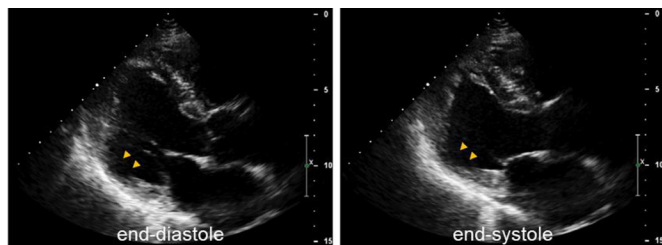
Echocardiographic findings. Transthoracic echocardiography in left ventricular long-axis view reveals an aneurysm with a wall thickness of 4.0mm on the inferior wall (yellow arrow). Left ventricular function is severely decreased with a left ventricular end-diastolic dimension of 55 mm (left panel) and a left ventricular end-systolic dimension of 46.5 mm (right panel). No valvular disease is observed.
